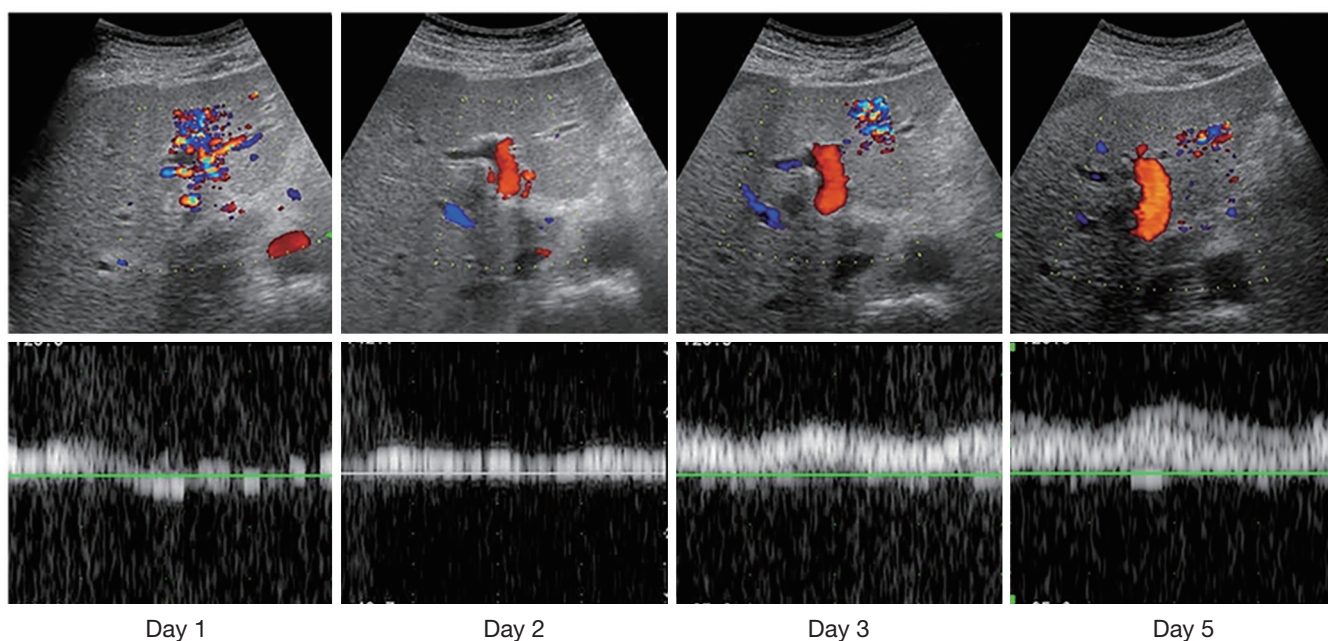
Doppler ultrasound imaging at admission shows a to-and-fro pattern of portal flow. The flow gradually increased in parallel with the improving hepatic function.
